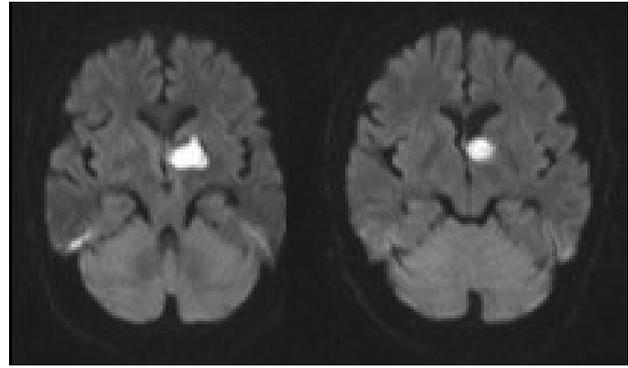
Inrain MRI demonstrated restriction diffusion changes in favor of ischemic changes in left basal ganglia
